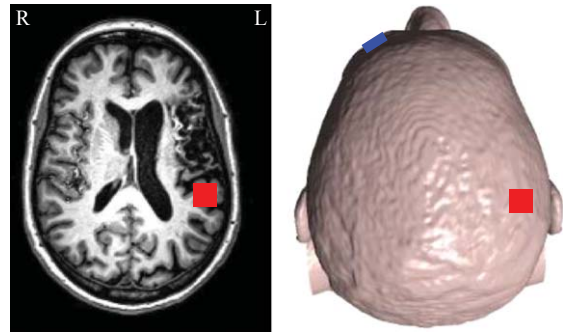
Perilesional stimulation site for a participant with left frontal lesion. The structural MRI on the left shows the left frontal lesion and the approximate location of the electrode projected on the head model is shown on the right. Red square indicates anode electrode placement (left temporal cortex) and blue square indicates cathode electrode placement (right forehead).
